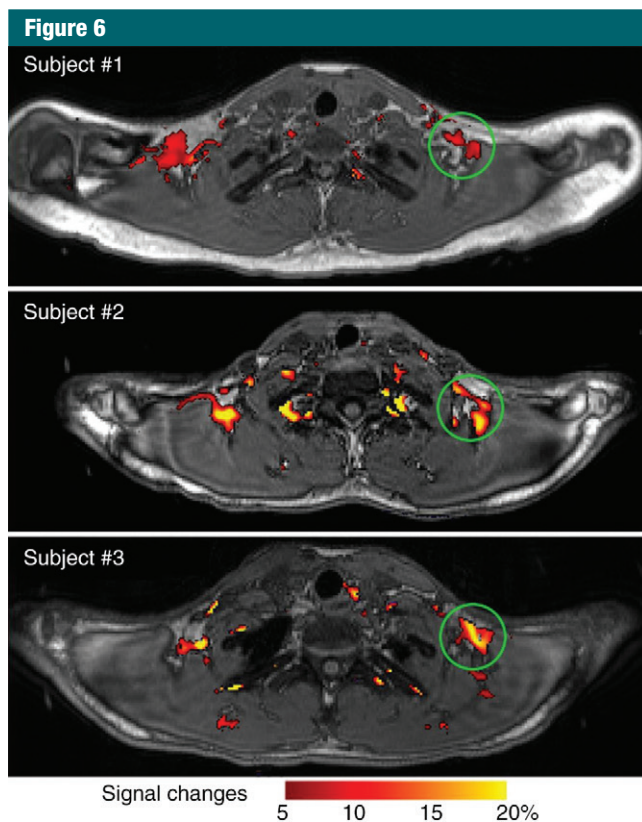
Detection of BAT activation in three human subjects with functional MR imaging. Significant BOLD signal changes (increasing from red to yellow) were detected after cold challenge (13° – 16° C) and superimposed on anatomic images. Green circles indicate areas of cold-activated BOLD signal. (Reprinted, with permission, from reference 86.)
